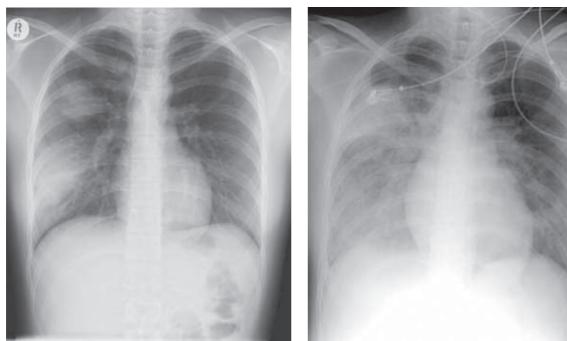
Chest radiograph on day 7 shows progression of air-space shadowing in the right lung.
